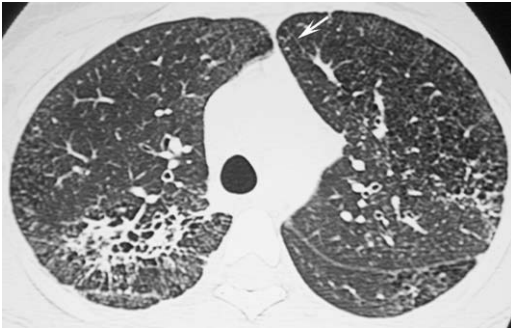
Parenchymal band in a patient with sarcoidosis. Axial HRCT through the upper lobes shows a thin, linear opacity in the medial left upper lobe (*arrow*), consistent with a parenchymal band. Note presence of traction bronchiectasis secondary to fibrosis related to sarcoidosis.
